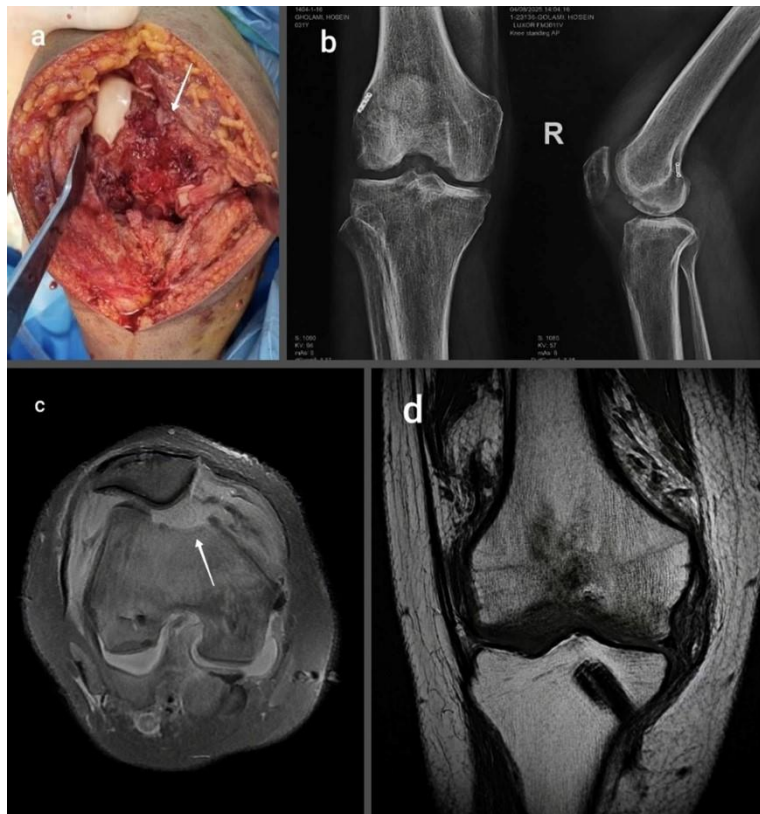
Post-ACL reconstruction osteomyelitis with associated cartilage and subchondral bone destruction. (A) Intraoperative photograph demonstrating the osteochondral lesion; the arrow indicates extensive loss of articular cartilage and underlying subchondral bone. (B) Anteroposterior and lateral radiographs of the knee; the arrow on the lateral view highlights the osseous defect. (C) Axial T2-weighted MRI showing the lesion involving the medial femoral condyle, while the lateral condylar cartilage remains preserved. (D) Coronal T1-weighted MRI demonstrating the extent of the osteochondral and subchondral bone involvement
